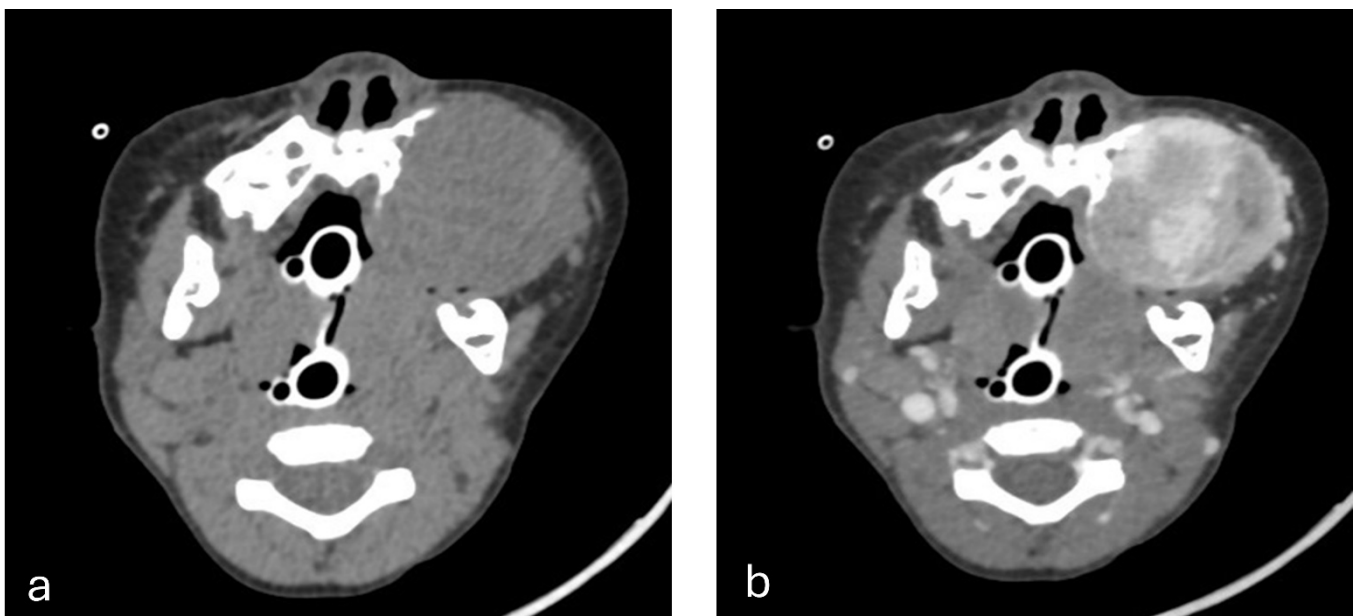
Axial pre-contrast CT image at the level of the maxilla
